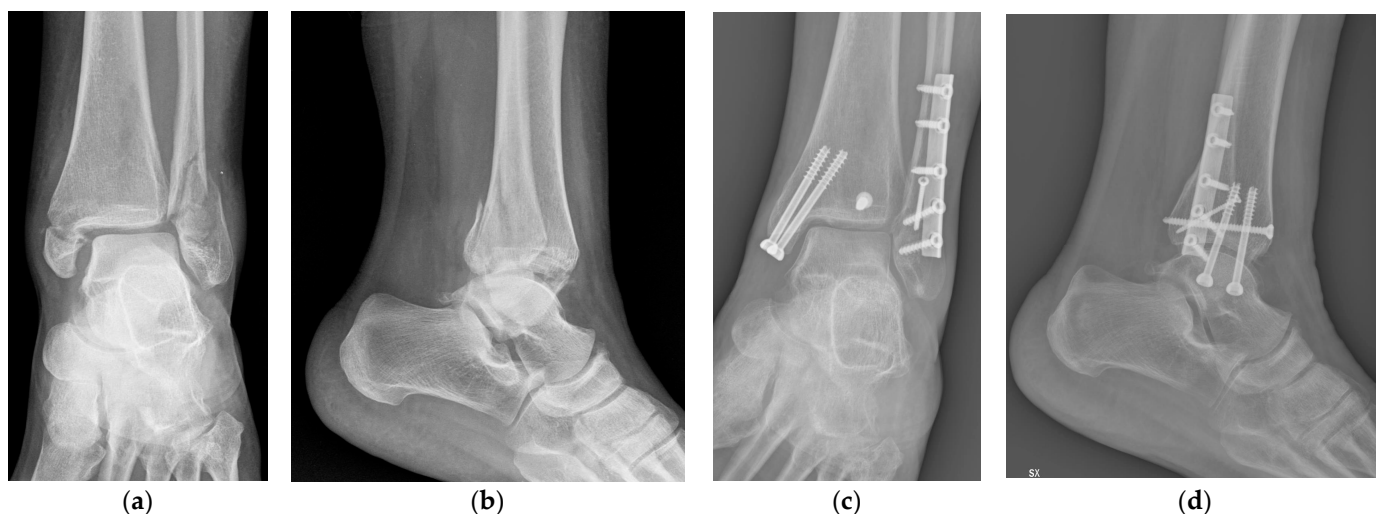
X-rays of trimalleolar ankle fracture in AP (a) and laterale views (b); post-operative X-rays of posterior malleolus fixation with percutaneous screw in AP (c) and laterale views (d).
